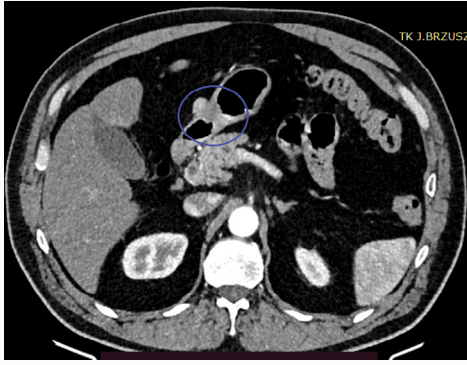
CT indicating tumor 17 × 15 mm in the anterior pyloric wall.
